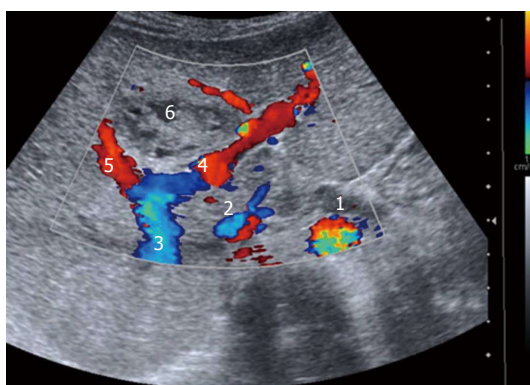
Doppler-US of the liver allows to investigate the relation between the tumor and the hepatic vessels. 1: Aorta; 2: Inferior vena cava; 3: Hepatic portal vein; 4: Left portal vein; 5: Right portal vein; 6 Tumor.
